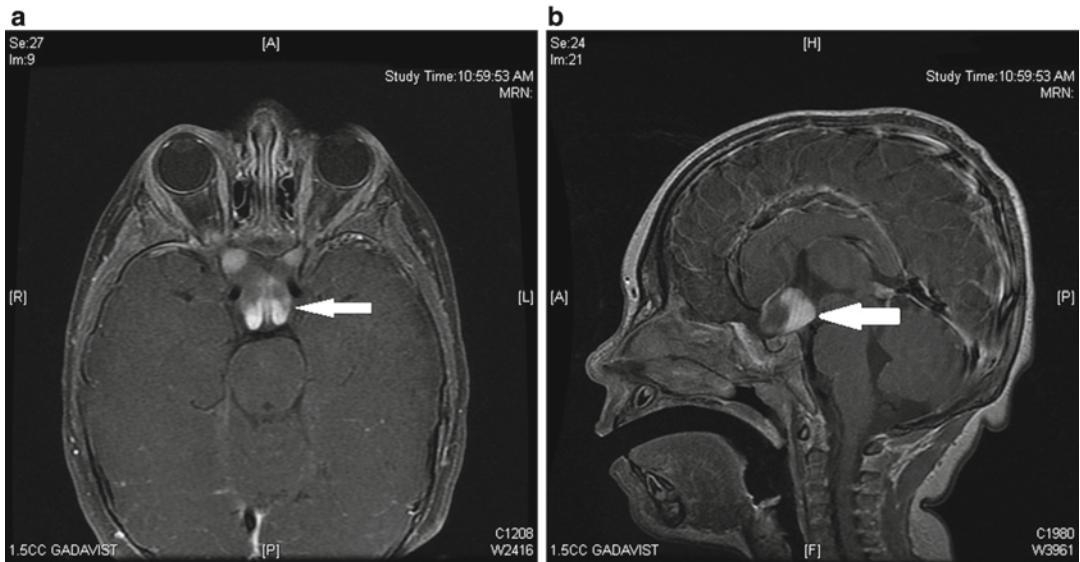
MRI with optic glioma shown in axial (a) and sagittal (b) views
